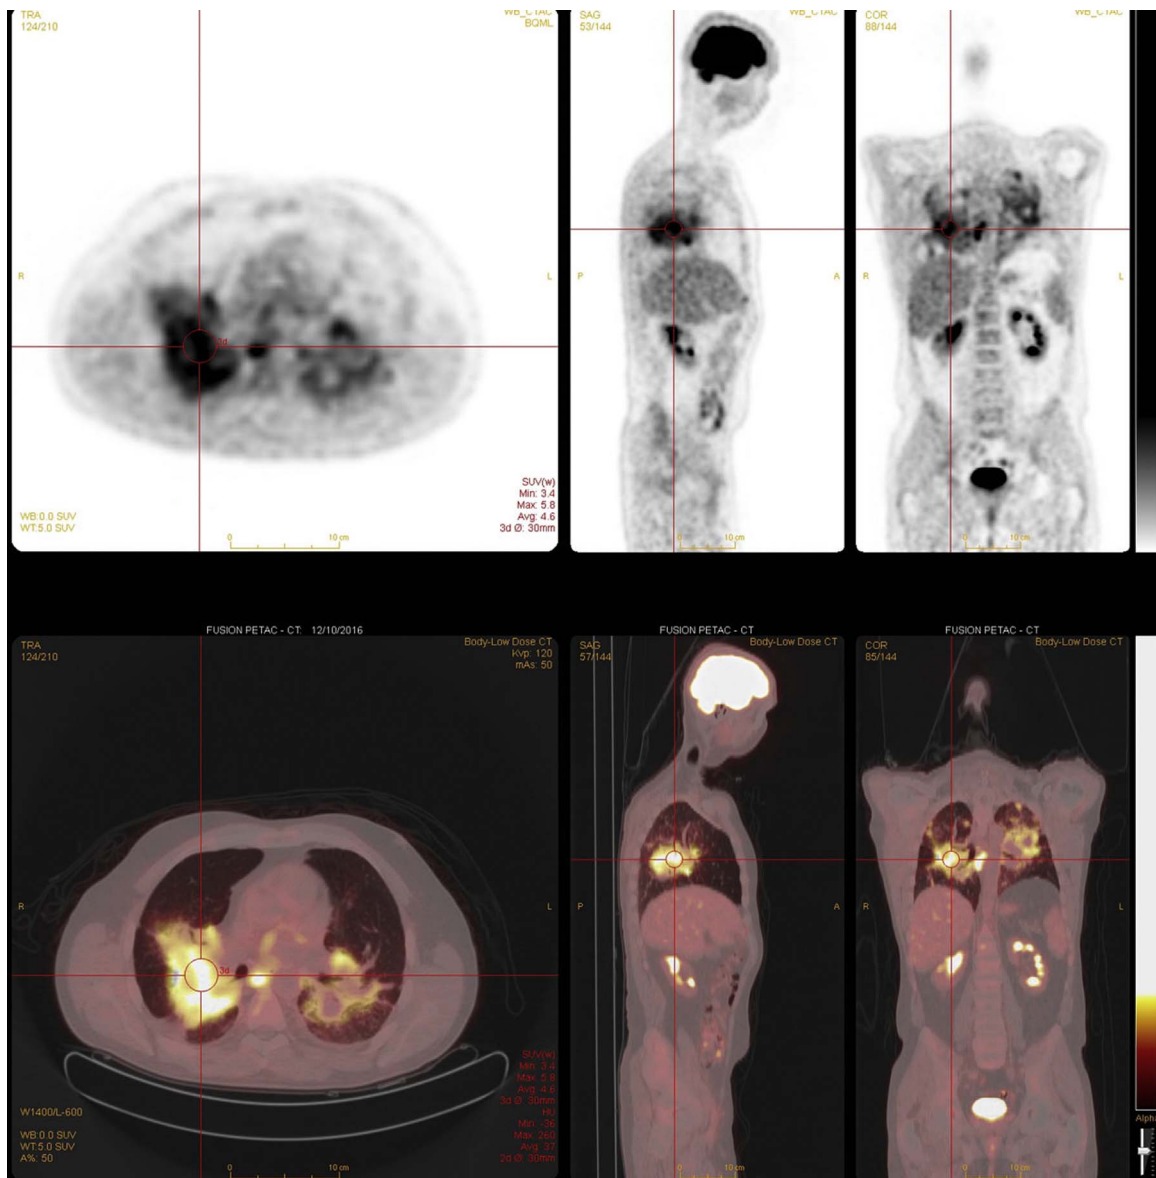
FDG-PET/CT scan showing increased pulmonary uptake.
